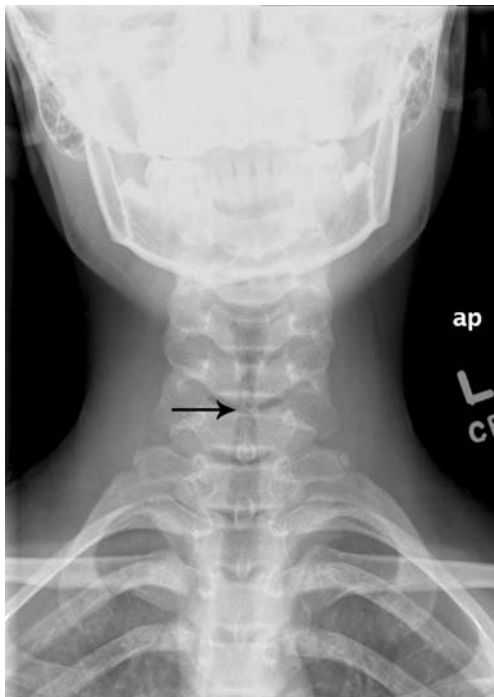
Radiograph, frontal view
